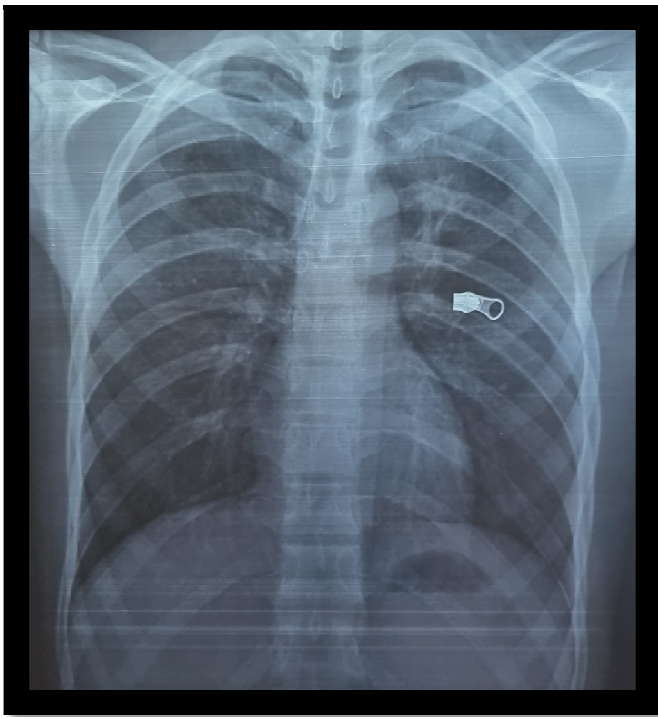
Chest X-ray centered on the domes
